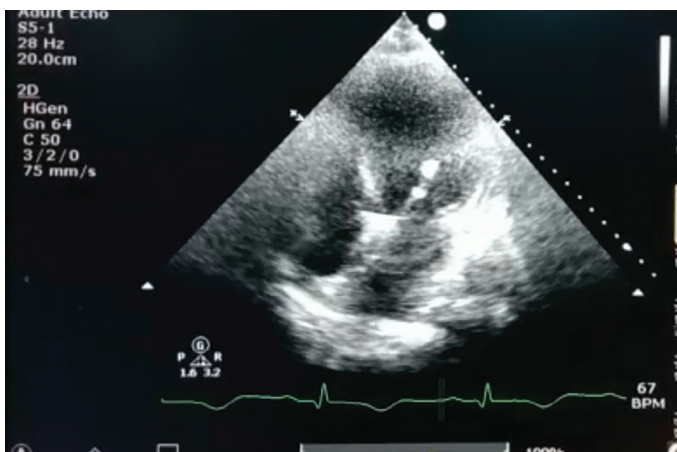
Transthoracic echocardiography showing a regular mass measuring 13 mm x 10 mm located on the anterior mitral leaflet
